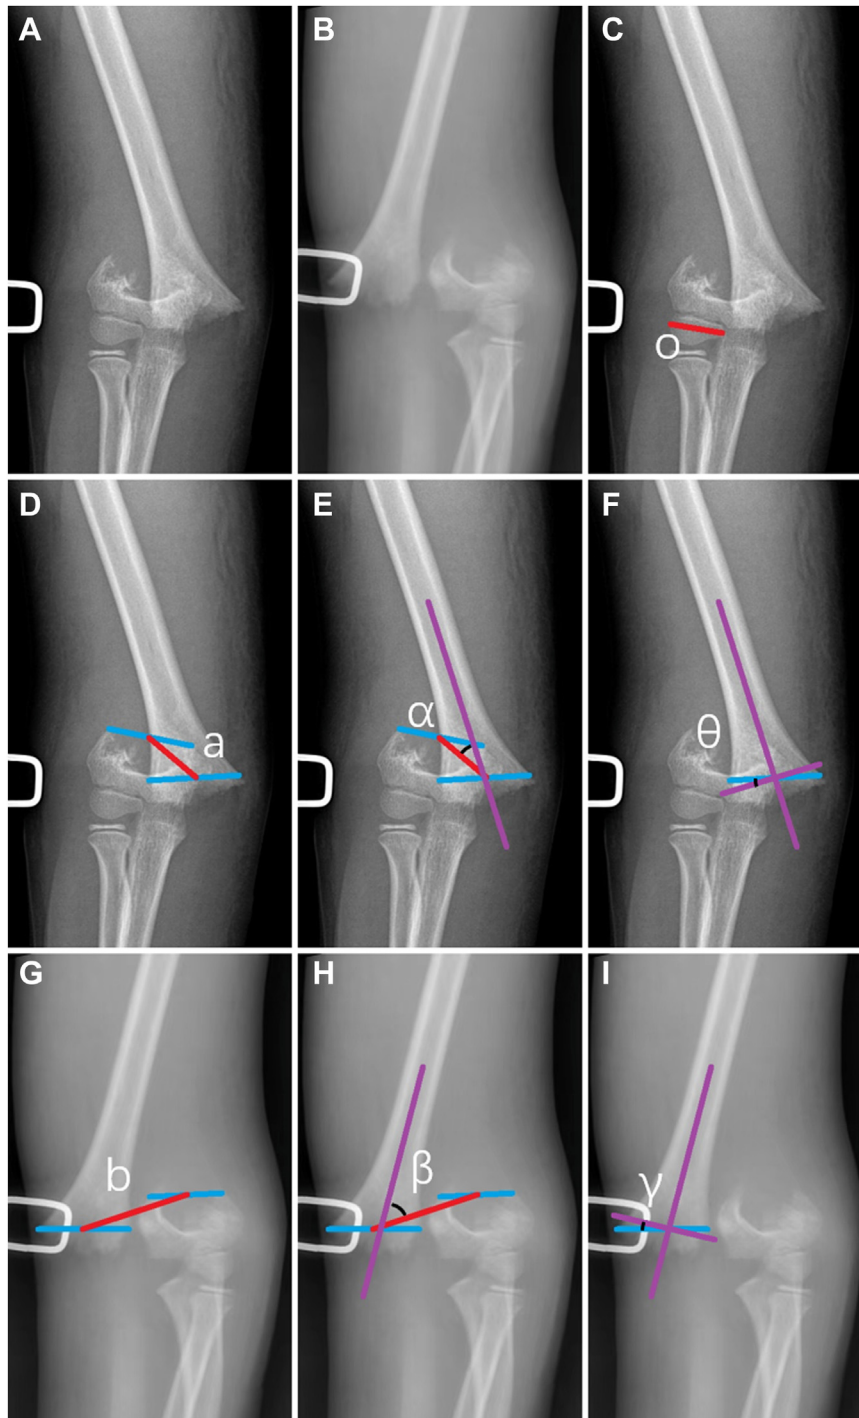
X-ray images of a male patient (age, 9.45 years) with Gartland III supracondylar humerus fracture. (A–I) Same as Figure 1.
